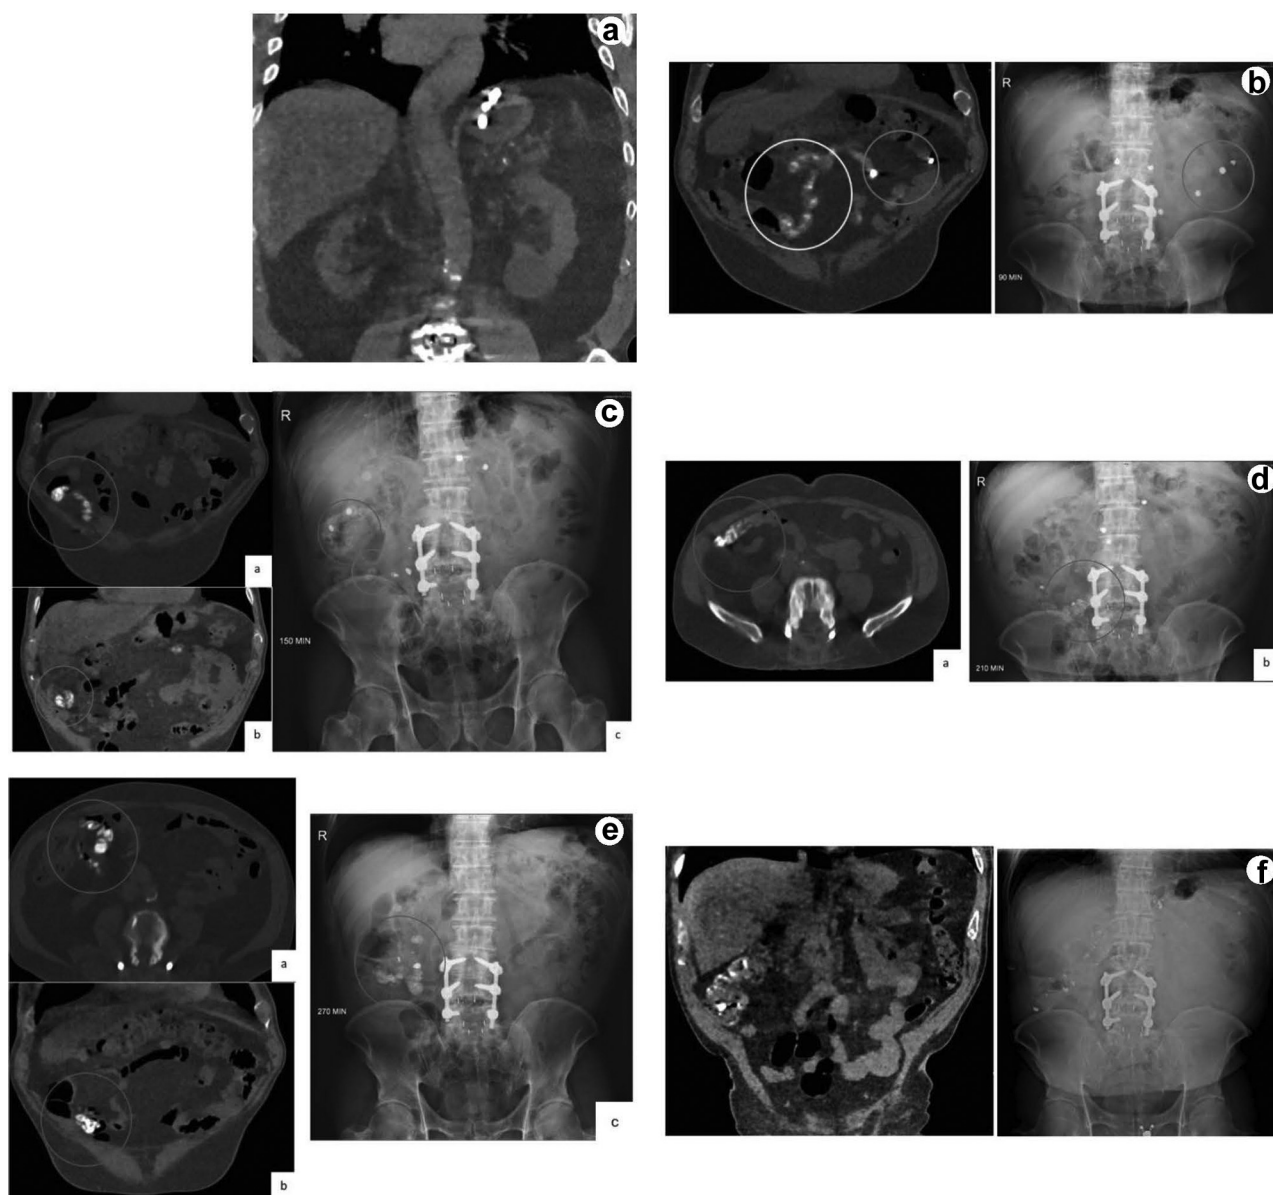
(a) Coronal ultra-low-dose CT (ULDCT) showing entire capsules arriving in the stomach at 0 minute. (b) Coronal ULDCT and X-ray (right) showing breaking up of the 3 capsules into larger capsular fragments in the jejunum (blue circle). Also start of release of punctiform particles seen on CT (yellow circle), but not obvious on X-ray. (c) a, b, c. Coronal ULDCT (a, b) and X-ray (c) shows the release of small particles in the distal portion of the ileum 150 minutes after ingestion of entire capsules of trcLanth.Carb. (blue and green (idem ...) circles indicating the corresponding areas). (d) a, b. Coronal ULDCT (a) and X-ray (b) shows slow distal progression of the larger capsular fragments and accumulation of punctiform particles in the distal ileum (blue circle) after 210 minutes. (e) Three larger capsular fragments containing lanthanum are still seen. (f) Coronal ULDCT (left) and X-ray image (right) showing all lanthanum punctiform particles within the colon after 360 minutes. CT, computed tomography.
